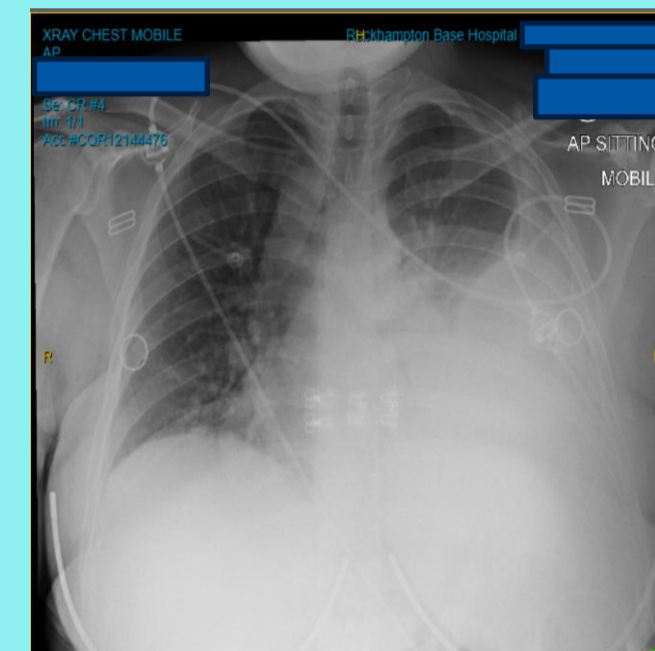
Chest X-ray revealed mediastinal displacement to the right secondary to a large left-sided pleural effusion and suspected left lower lobe consolidation.
